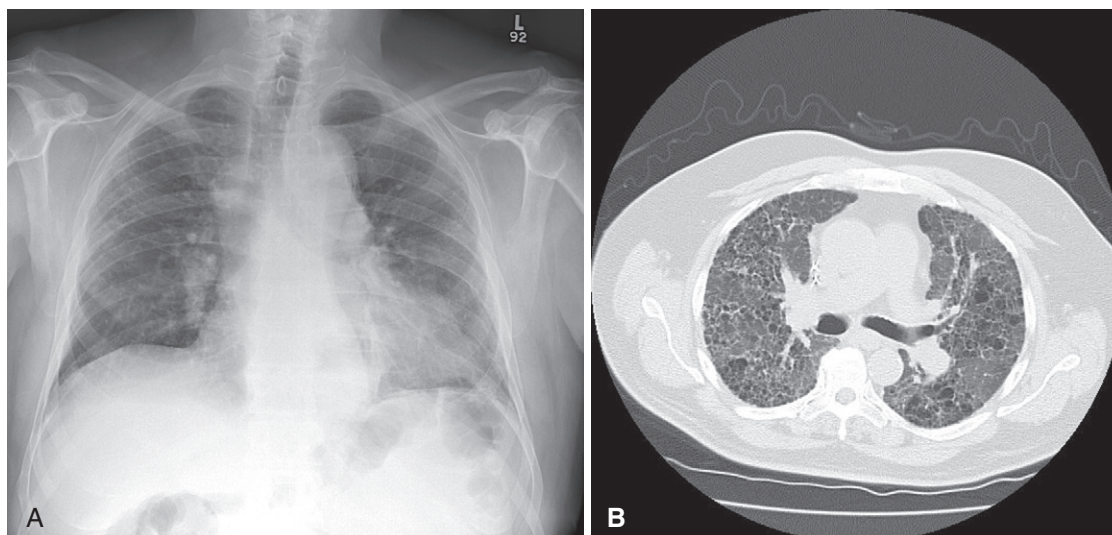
Posteroanterior chest radiograph (A) and high-resolution computed tomography scan (B) from patients with chronic beryllium disease. The chest radiograph demonstrates hilar adenopathy and infiltrates, and the scan shows air space destruction and infiltrates.
